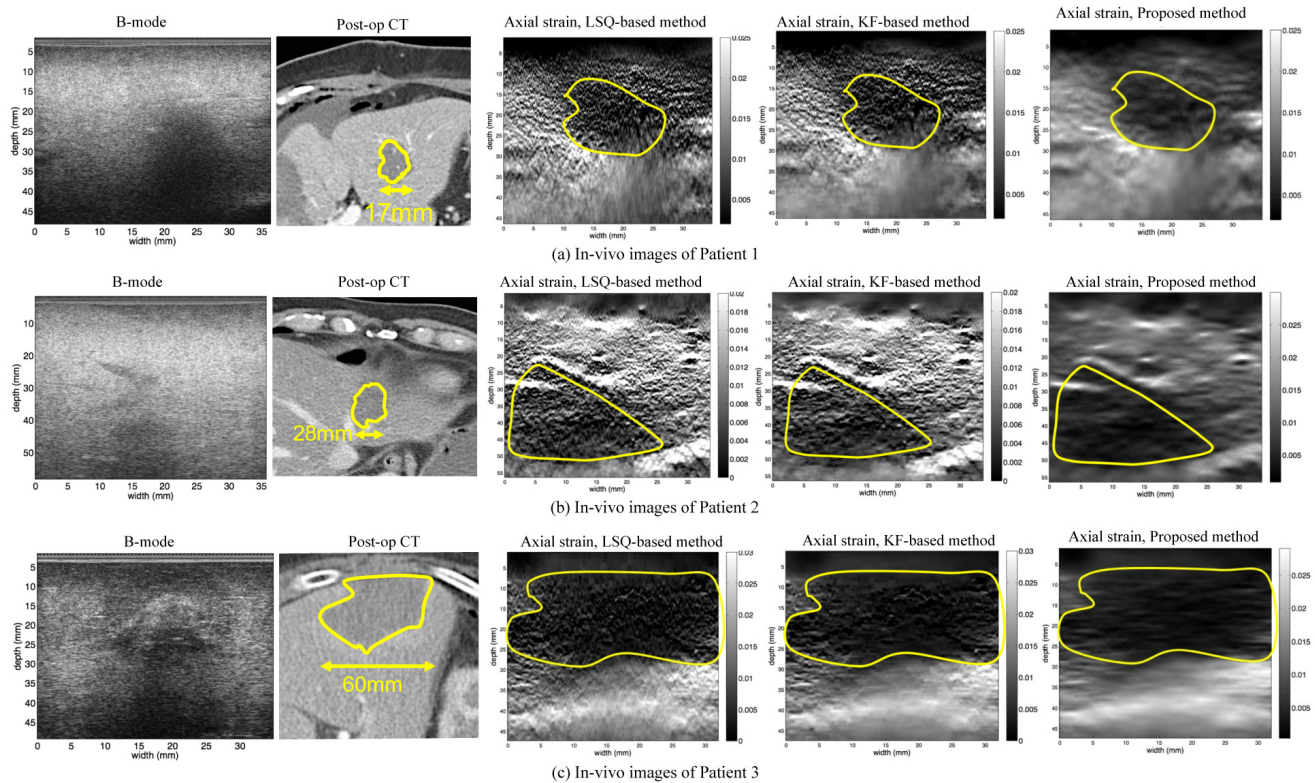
In-vivo* images of the thermal lesion of RF ablation therapy of the liver cancer. The thermal lesions are delineated manually in yellow, and are not visible in the B-mode images. The corresponding post-operative CT images with the delineated lesion boundaries are also shown.
